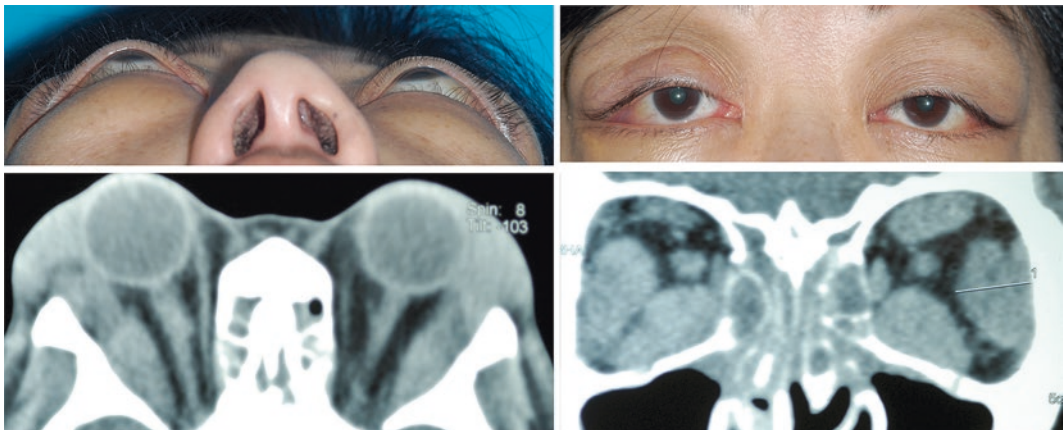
CT of a middle-aged female with definite IgG4 related ophthalmic disease showing bilateral lacrimal gland, inferior and lateral recti, and left superior rectus enlargement. Clinically she showed bilateral proptosis, lid swelling and the classic “S-shaped” ptosis. Noted the bilateral ethmoid sinusitis
